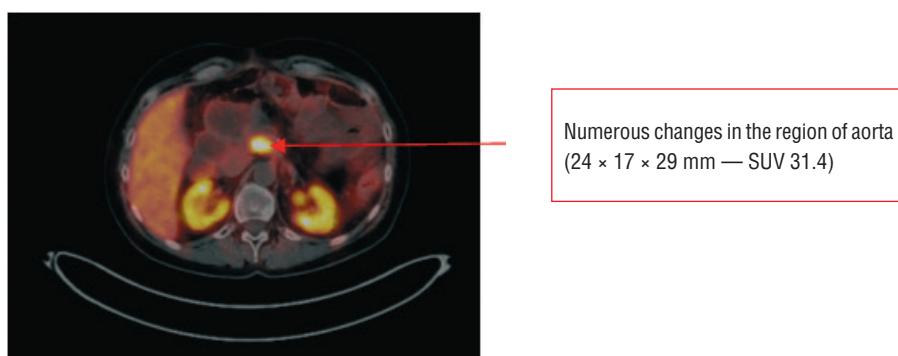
Image of the ^{68}Ga -PET/CT scan shows expression of somatostatin receptors in numerous changes of region of aorta
